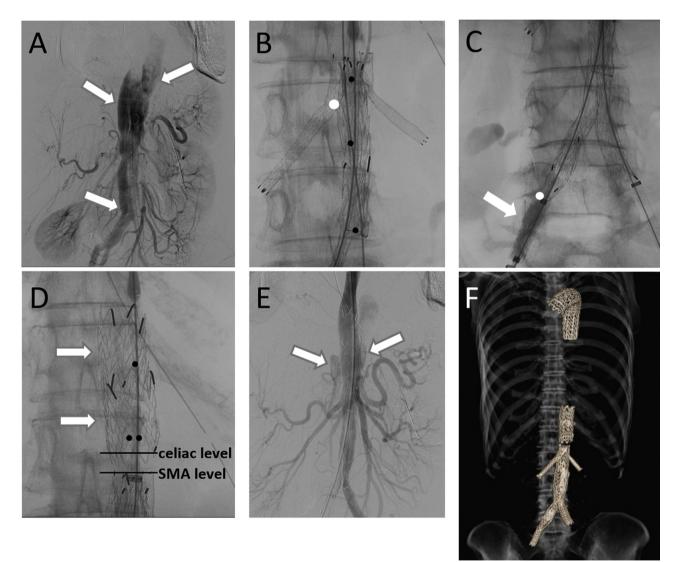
Multiple re-entry closures using aortic and branch endografts following TEVAR. Dots indicate the sites of re-entry tear. (A) After TEVAR, abdominal true lumen aortography showed marked ascending blood flow in the thoraco-abdominal false lumen (FL; arrows). (B) Re-entry at the detached right renal artery (RA) ostium (white dot) was closed using a covered stent. Re-entries at the detached right lumbar arteries (black dots) were closed by endovascular aneurysm repair, and both RAs were spared using the chimney technique. (C) Re-entry at the right iliac bifurcation (white dot) was closed by an iliac extender (arrow). (D) Two aortic extenders (arrows) were placed to close re-entries at the ostia of the detached bilateral inferior phrenic and left twelfth intercostal arteries (black dots) above the coeliac artery. (E) Completion aortography showed remaining FL retrograde flow from the re-entry at the ostium of the detached right first lumbar artery located between the coeliac and superior mesenteric artery (SMA), but it was significantly diminished (arrows). (F) Post-procedural three dimensional computed tomography (without contrast enhancement) shows all deployed endografts and the endovascular procedures that were performed.
